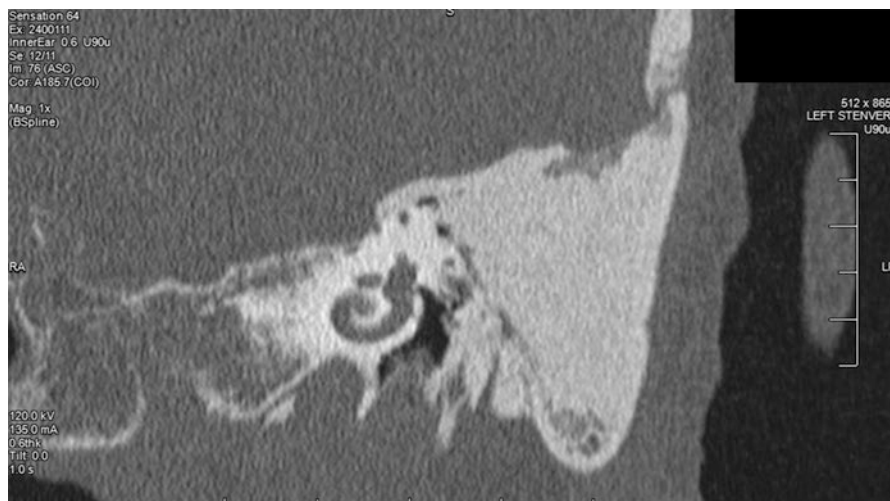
Postoperative CT scan after combined transmastoid/middle fossa craniotomy resurfacing with calvarial bone and obliteration with HA cement
